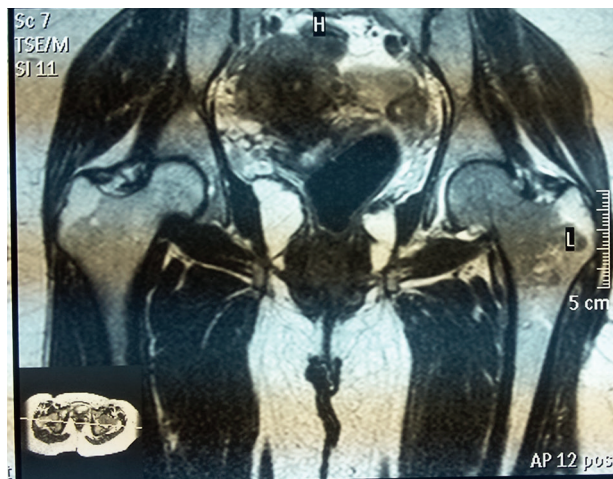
MRI (T1) of the bone and hip joints showing marrow signal changes in the head of left femur suggestive of a skeletal metastatic lesion.
